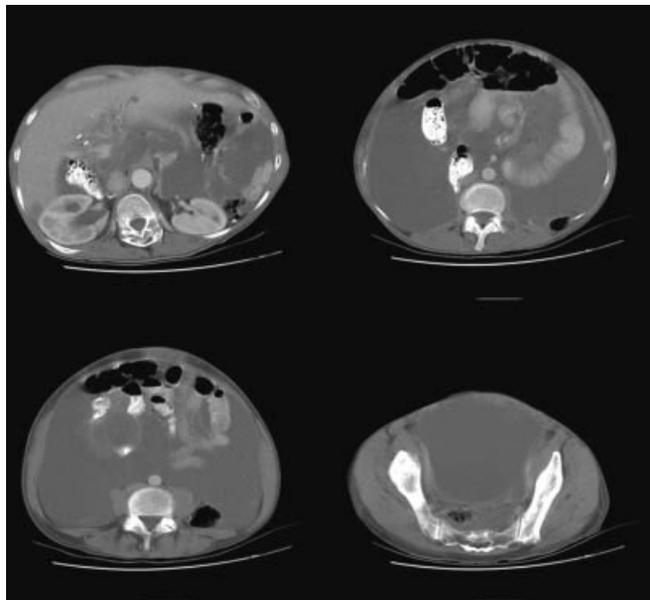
Representative CT Scan images (March 9, 2004) 4 years after second operative intervention without HIPEC demonstrating extensive mucinous peritoneal carcinomatosis.
